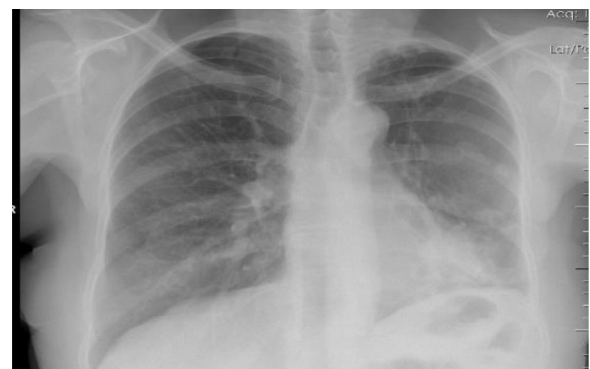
Chest-Xray after foreign body removal showing fibrosis, bronchiectasis and reduced left lung volume with few small bullae in upper pole.
